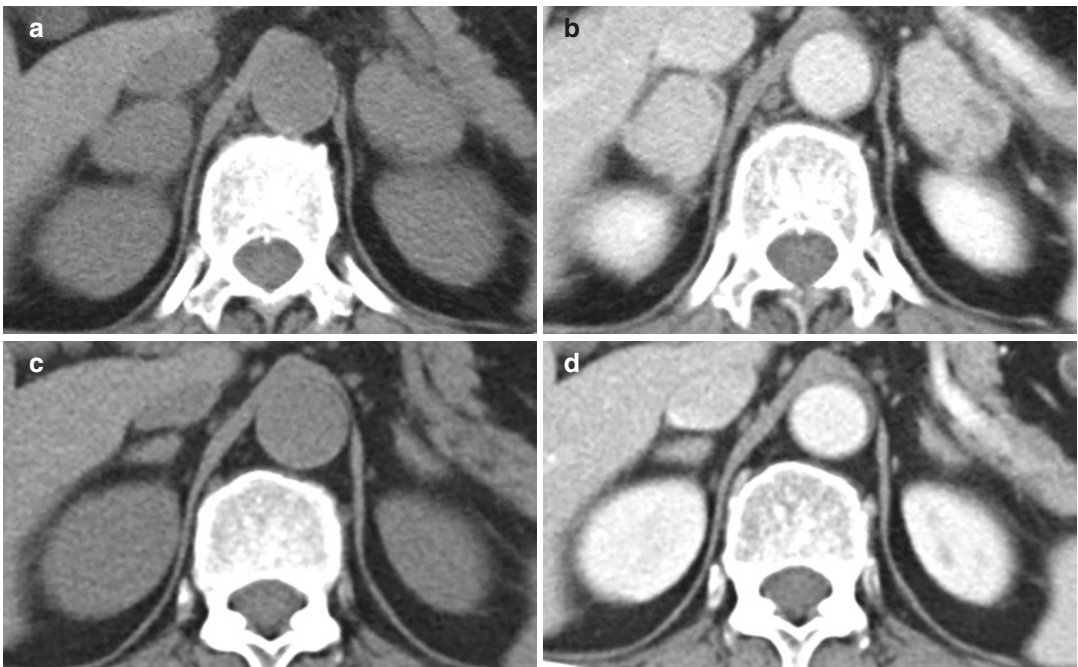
Bilateral adrenal TB in a 73-year-old woman with pulmonary TB. Axial (a) unenhanced and (b) contrast-enhanced CT images show bilateral adrenal enlargement with homogeneous enhancement. Follow-up
